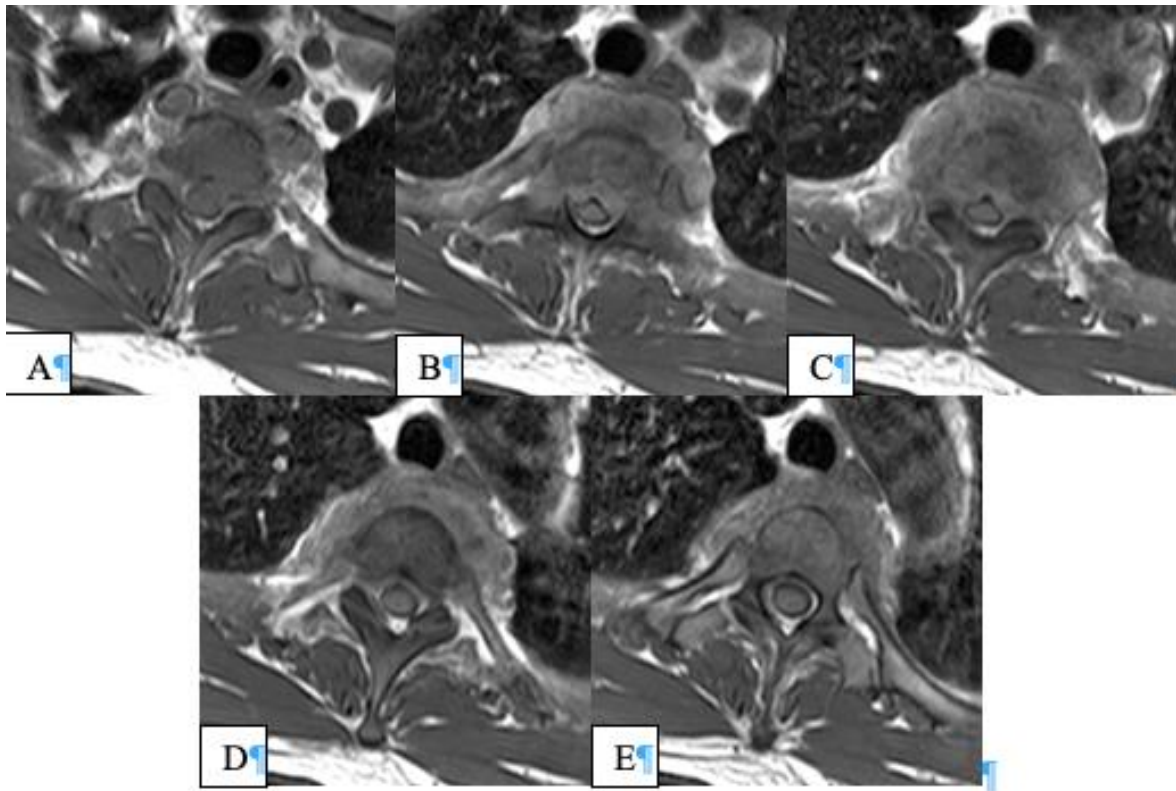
T1W Axial view of MRI at level of Th1 (A), Th1-2 (B), Th2 (C), Th2-3 (D), Th3 (E)
